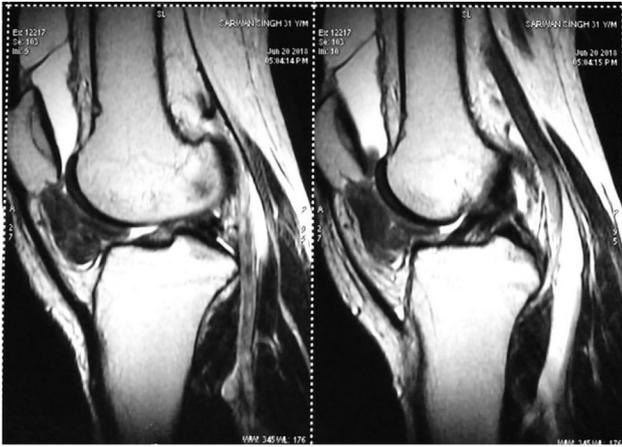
MRI of the knee joint.
